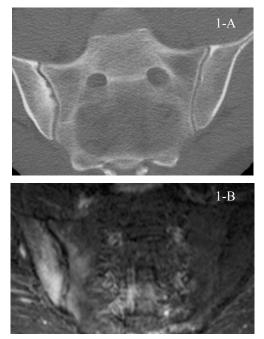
Images of bilateral sacroiliitis in a 31-year-old woman with suspected sacroiliitis. a) CT scan showing two erosions and sclerosis on the right iliac surface. b) STIR sequence obtained in the same section position as 'a' demonstrates abnormal high signal in the cartilaginous portion of the right sacroiliac joint and abnormal increase in signal in the adjacent iliac subchondral marrow, indicating active inflammation.
